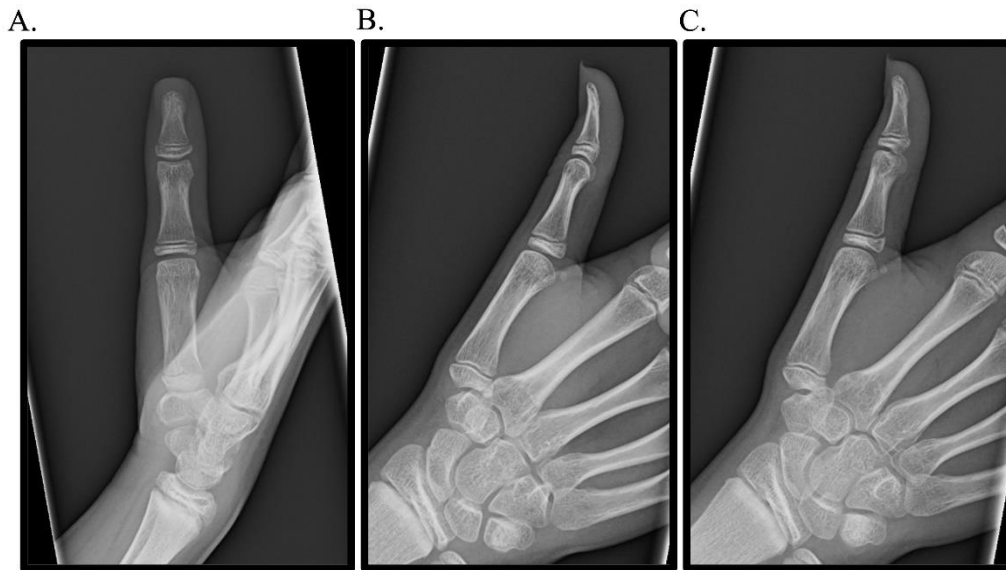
PA (A), lateral (B), and oblique (C) radiographs of the right thumb in a skeletally immature individual, obtained four weeks post-injury, demonstrating interval healing of a previously minimally displaced Bennett-equivalent metacarpal base fracture with preserved carpometacarpal joint congruity
